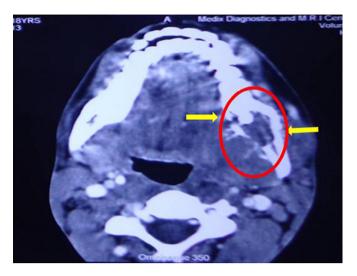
CT scan revealing ill defined osteolytic lesion within body and ramus of left mandible causing erosive destruction of overlying cortices and showing periosteal new bone formation giving a sun ray appearance (case #2).
